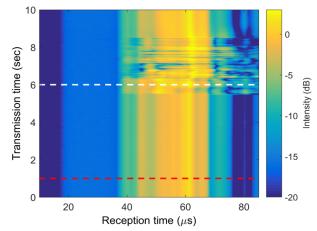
Temporal change in intensities of the received signals. Longitudinal axis shows the ultrasound transmission time. Lateral axis shows the reception time based on each transmission time.
